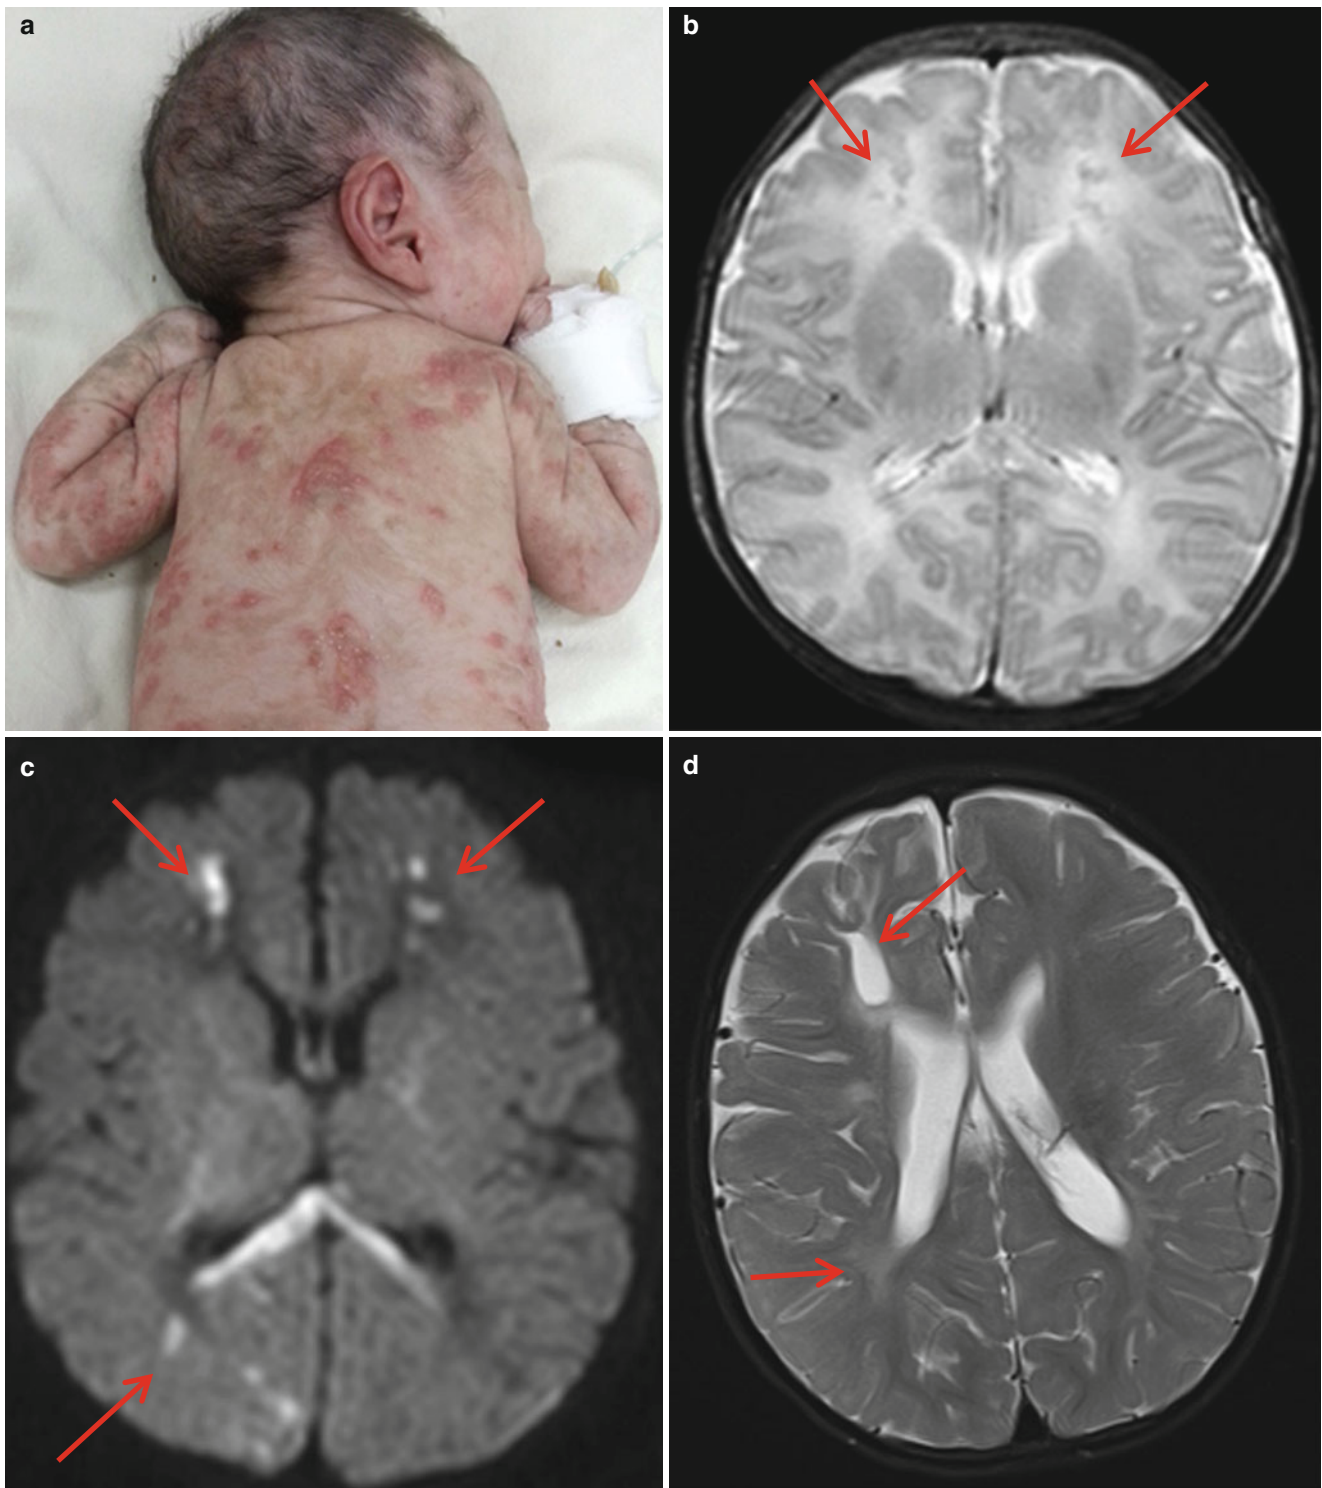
Incontinentia pigmenti. (a) Newborn infant shows generalized skin desquamation and blister formations. (b) T2-weighted image shows multiple nodular low signal lesions (*arrows*). (c) Diffusion
